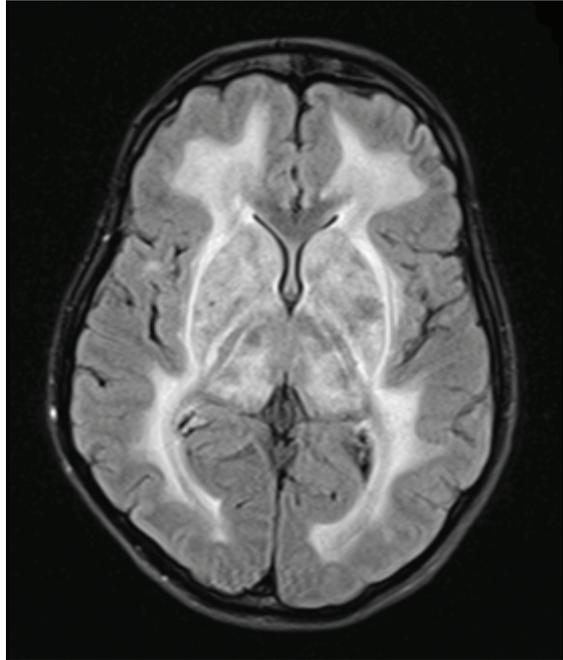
FLAIR sequence MRI brain showing subcortical leukodystrophy sparing the corpus callosum
